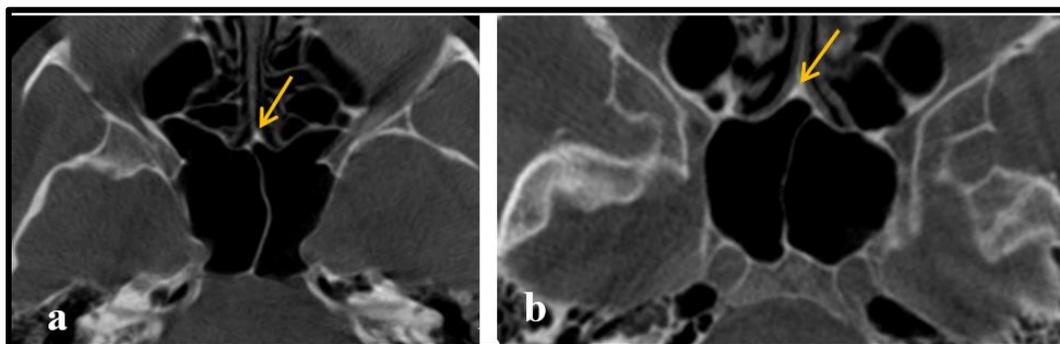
Axial cuts of CBCT showing the anteriolateral and posterior extension of the sphenoid sinus: a) anteriolateral extension with critical type, b: No anterior extension with non critical type. Note: arrows indicate sphenoidal crest
